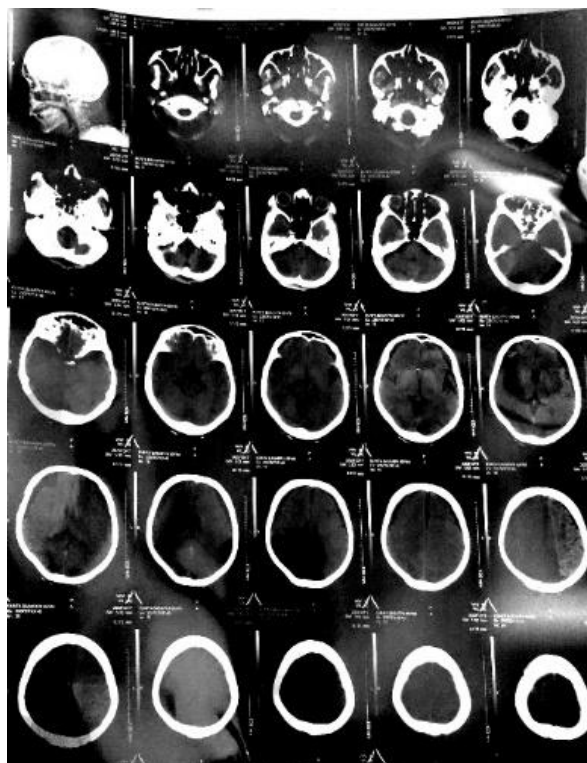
CT Brain suggestive of no significant neuroparenchymal abnormalities are seen
